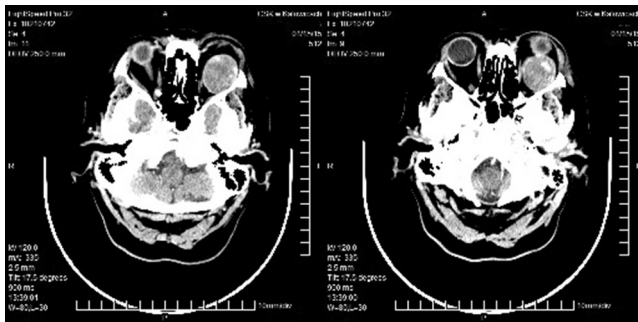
CT scans showing a giant retrobulbar tumor located in the upper medio-lateral compartment.
